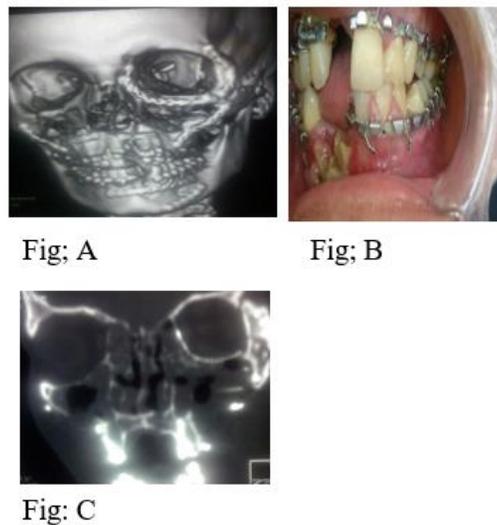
Postoperative view; (A) postoperative 3D CT; (B) postoperative occlusion; (C) coronal View.
